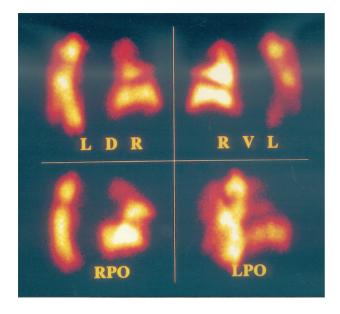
Massive multiple pulmonary embolism (perfusion scintigraphy) (with permission of Prof. K. H. Bohuslavitzki).
